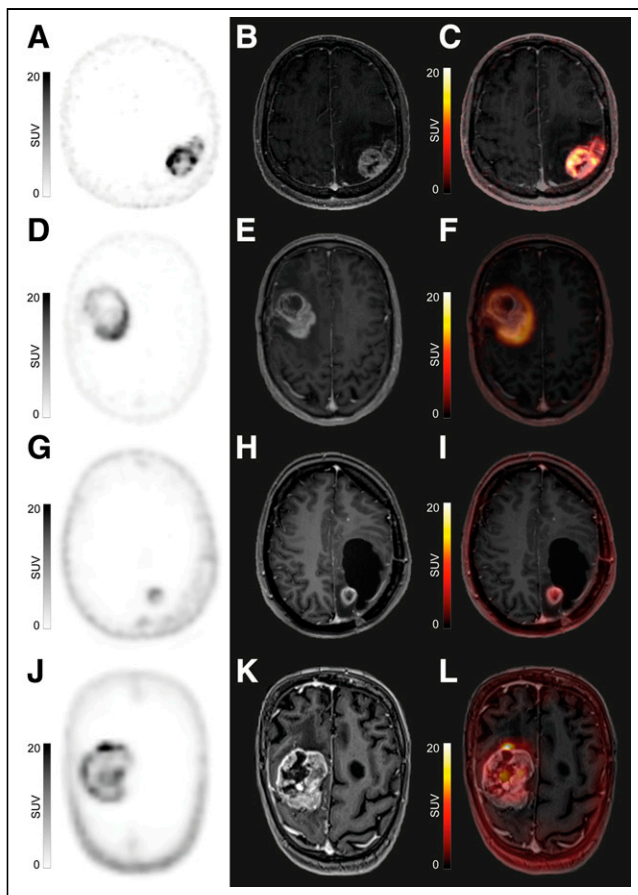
Selected examples of PET (A, D, G, and J), MRI (B, E, H, and K), hybrid PET/MRI (C), and fused PET/MRI (F, I, and L) of patients injected with [^{68}Ga]Ga-PSMA-11 (patient 1 from Erasmus MC [A–C], SUV_{max} , 20.0, and patient 10 from UMCU [G–I], SUV_{max} , 1.3), [^{18}F]DCFpyl (patient 8 from Amsterdam UMC [D–F], SUV_{max} , 13.1), and [^{18}F]PSMA-1007 (patient 14 from Radboudumc [J–L], SUV_{max} , 12.4). Note heterogeneity of tracer uptake within tumors.
